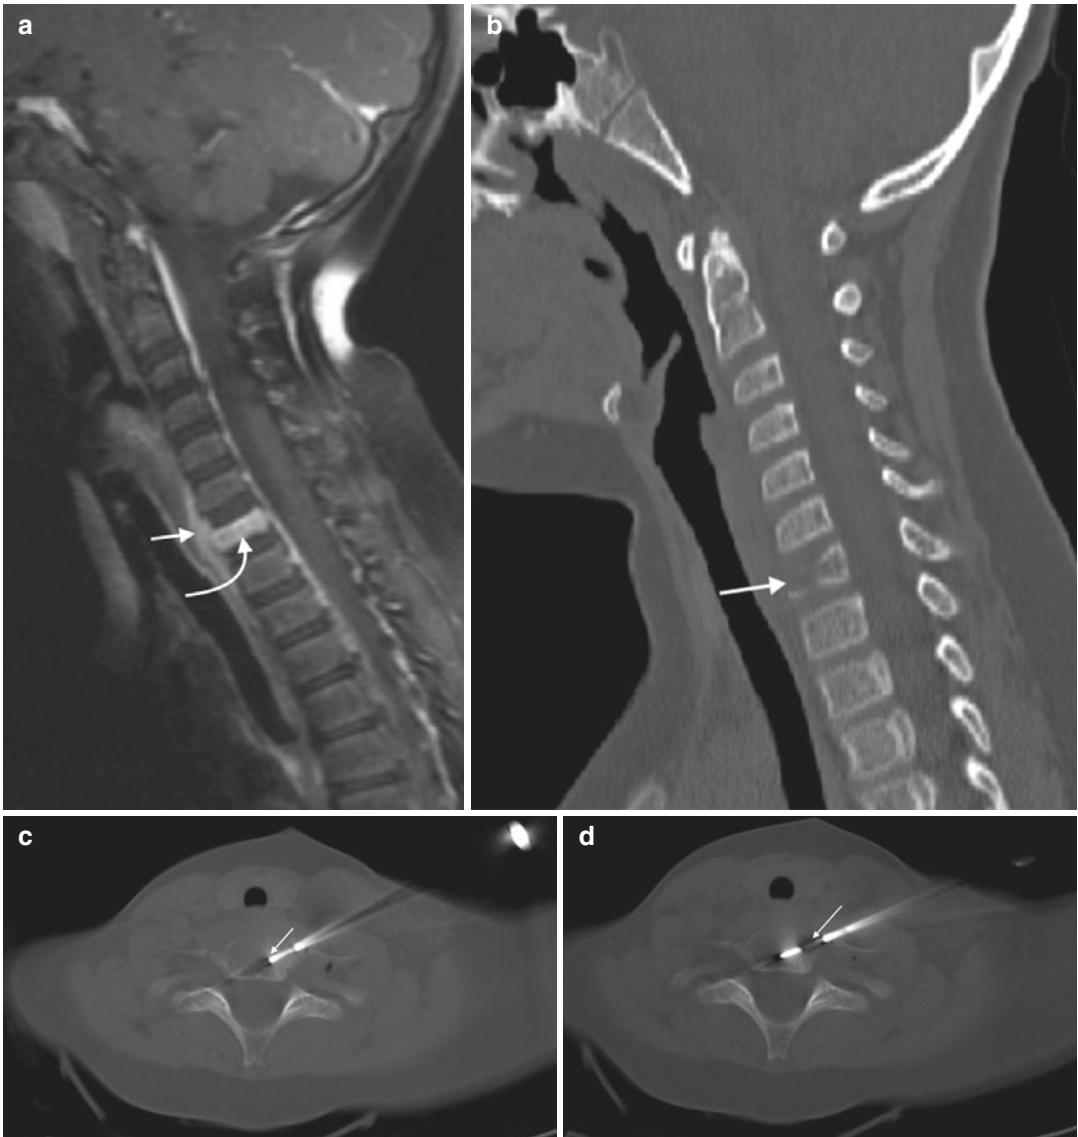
A 5-year-old male with neck pain. Fat-suppressed contrast-enhanced T1-weighted sagittal image (a) shows a partial C7 vertebral compression deformity that is associated with diffuse contrast enhancement (*curved arrow*) and focal prevertebral soft tissue enhancement (*arrow*). Sagittal CT reformation in bone window algorithm (b) shows a partially lytic lesion (*arrow*) at C7. Axial CT image (c) from biopsy procedure shows coaxial insertion
